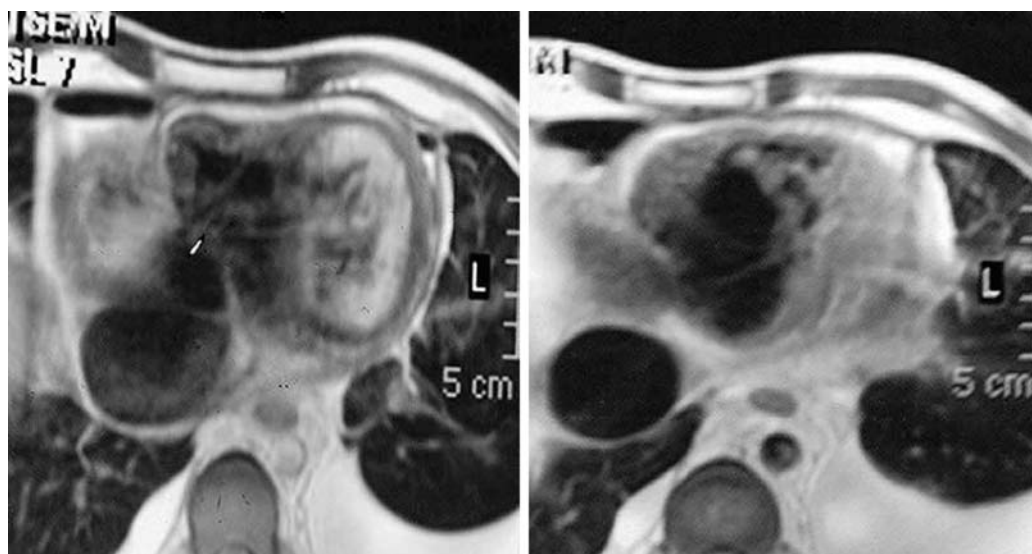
MRI sections showing increased tissue density in the right ventricle.
